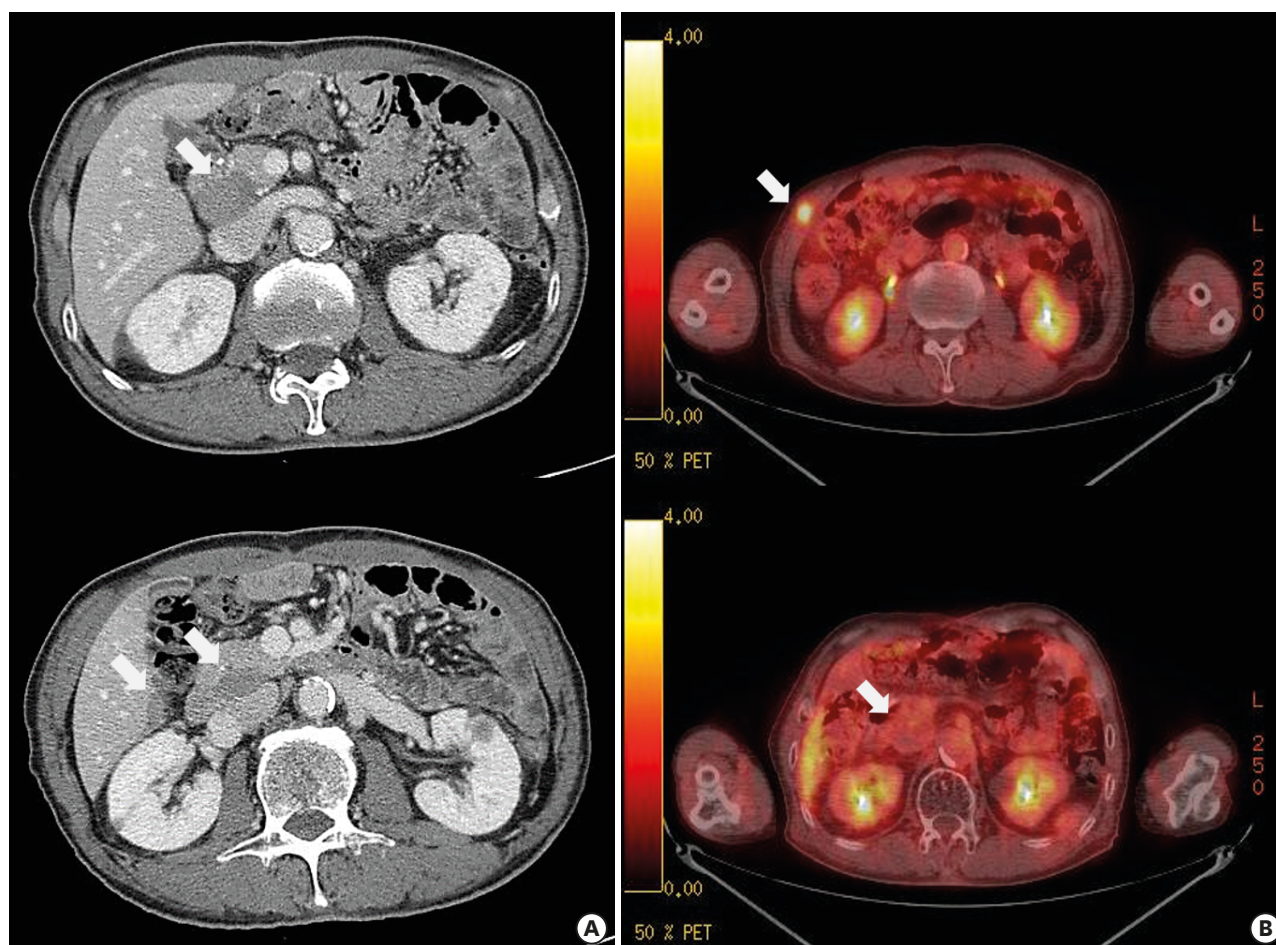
CT and PET scan at second recurrence to the abdominal wall. (A) CT of the abdomen revealed a 1-cm enhancing mass at the right abdominal wall. The peripancreatic LN, which was the first metastatic site, did not change with the partial response, and the LN at the inferior aspect of the right lobe of the liver had disappeared. (B) PET revealed ¹⁸F-FDG uptake in the mass at the right abdominal wall (standardized uptake value, 3.4) and no further ¹⁸F-FDG uptake including in the LNs at the peripancreatic and inferior aspect of the right lobe of the liver. CT = computed tomography; PET = positron emission tomography; LN = lymph node; ¹⁸F-FDG = 2-deoxy-2-[fluorine-18]fluoro-D-glucose.
